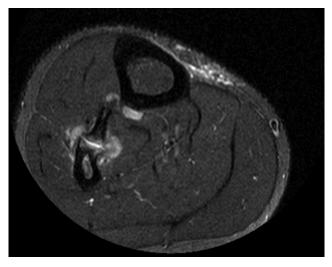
Magnetic resonance image depicting diaphyseal tibiofibular synostosis.
